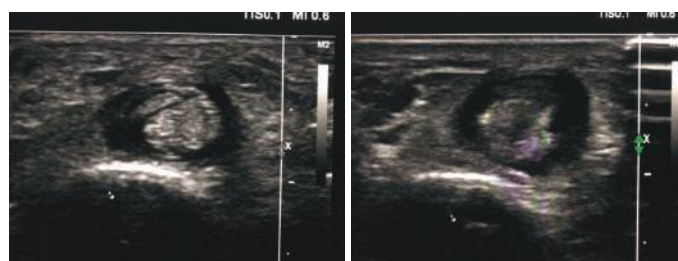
Ultrasound comparing affected digit with corresponding digit of opposite hand. Significant amount of fluid is seen surrounding the flexor tendon and is absent in unaffected finger.
